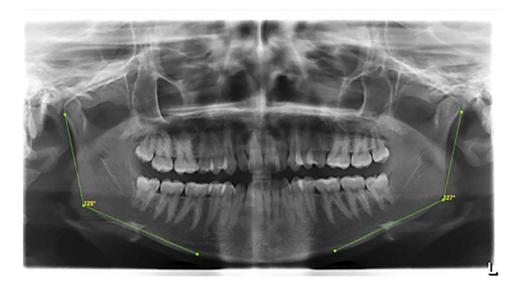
Gonial angle measured on a panoramic radiograph.
